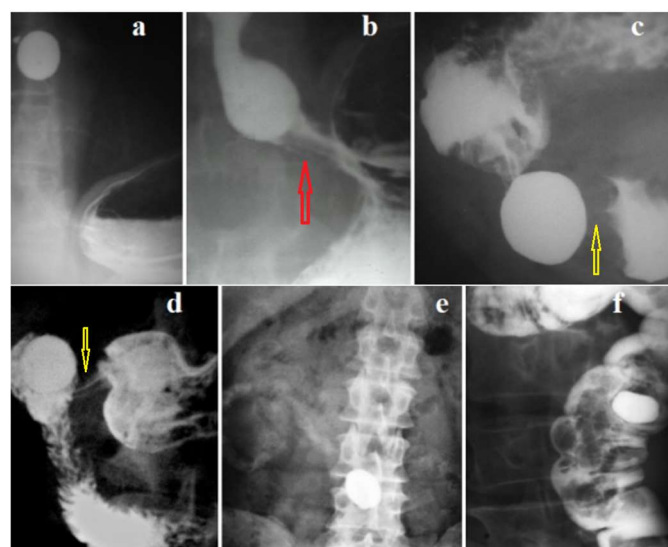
Radiographs from different studies demonstrating the movement of a contrast tablet through the digestive tract. (a). In the esophagus. (b). Above the lower esophageal sphincter (red arrow). (c). In the antrum of the stomach above the pyloric sphincter (yellow arrow). (d). In the duodenal bulb after passage through the pyloric sphincter (yellow arrow). (e). In the small intestine. (f). In the descending colon.
